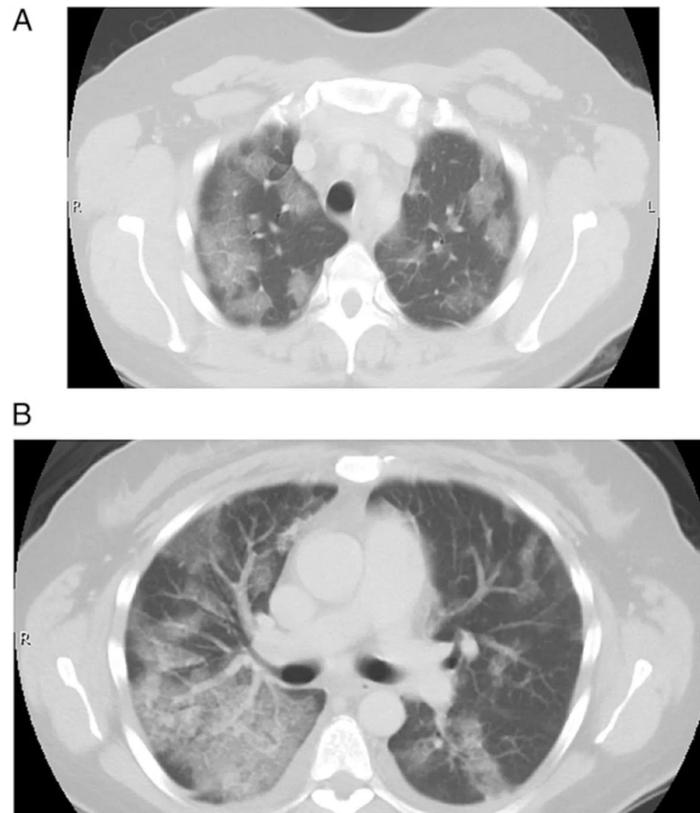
Representative CT images show the “crazy paving” pattern of patchy ground glass superimposed on interlobular septal thickening. A, Bilateral upper lobes. B, Bilateral lower lobes.
